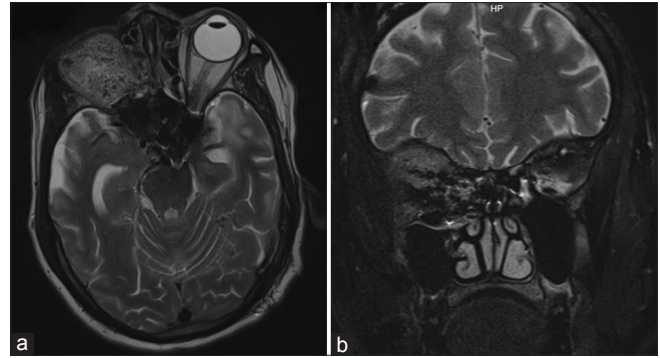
Postoperative (a) axial and (b) coronal cuts of magnetic resonance imaging of the brain showing exenterated right orbit with severed optic chiasma
